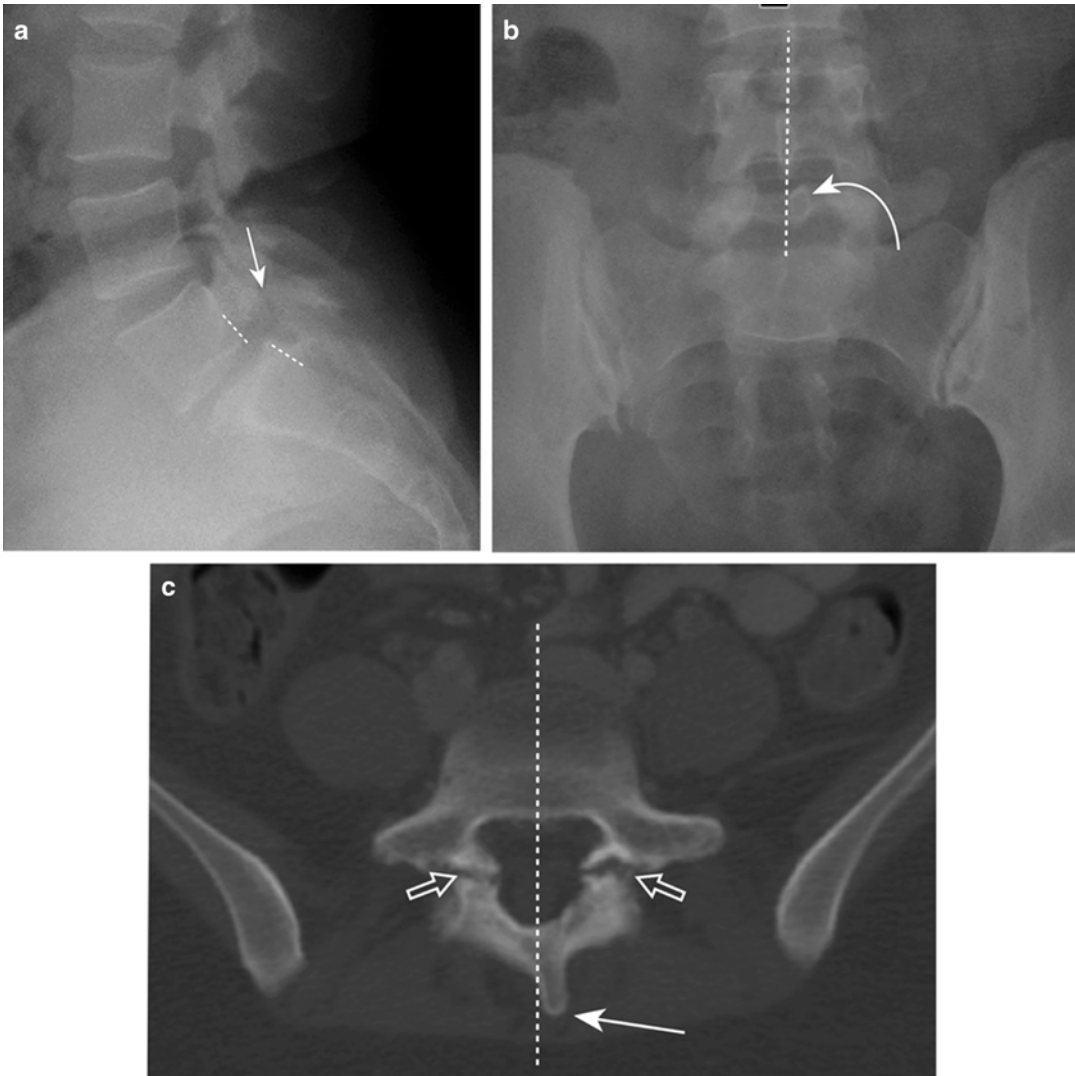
Spinous process rotation and tilt as signs of spondylolysis with spondylolisthesis. (a) Lateral radiograph demonstrates anterolisthesis of L5–S1 (*dashed lines*). There is spondylolysis at L5 (*arrow*). (b) On the AP radiograph, the spinous process of L5 (*curved arrow*) is rotated to the left of an extension of the *vertical line*
